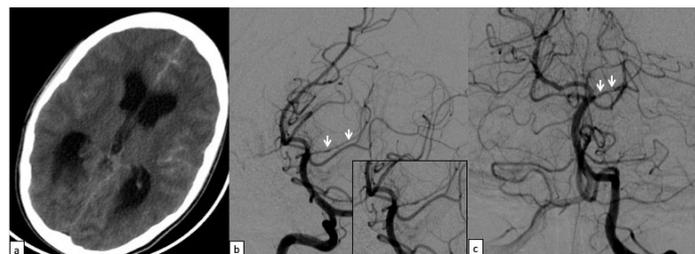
16 years old patient, with intracranial hypertension. (b, c): Non enhanced brain CT: massive subarachnoid hemorrhage, brain angiography in lateral (b) and frontal (c) views: irregular and lobulated appearance of the arterial surface of the left posterior cerebral artery with reduction of its caliber.
